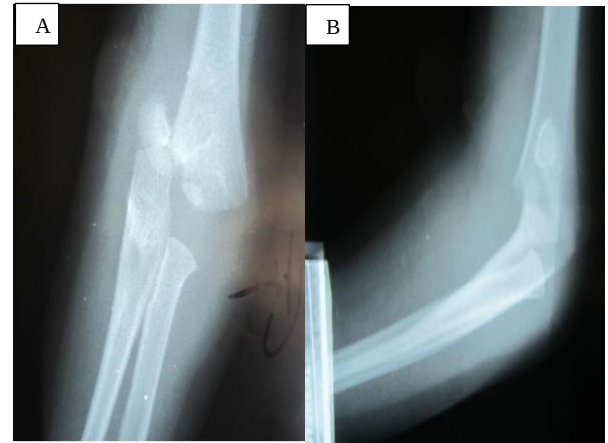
A) Anteroposterior (AP) elbow radiograph at presentation demonstrating a posteriorly displaced supracondylar/transphyseal fracture of the distal humerus with suspected medial physeal involvement; B) Lateral elbow radiograph at presentation confirming posterior displacement of the distal fragment relative to the humeral shaft, consistent with an unstable supracondylar/transphyseal pattern
